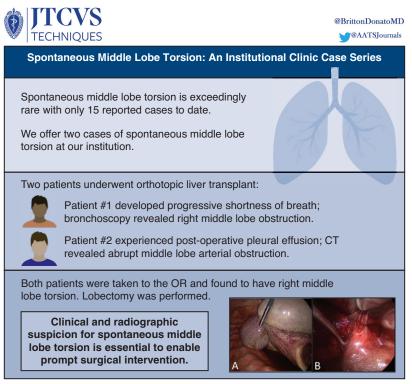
Shown are the methods, results, and implications of this study. CT, Computed tomography; OR, operating room.
